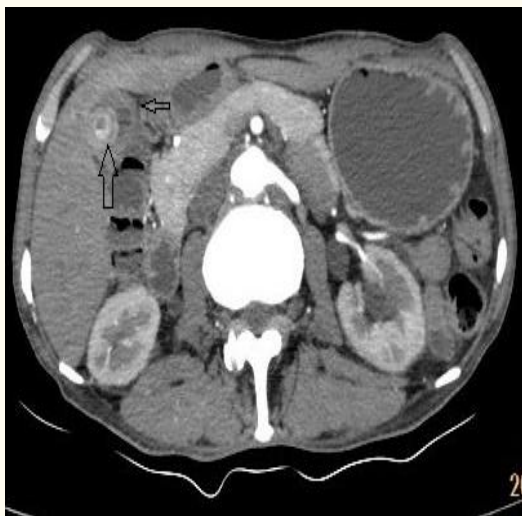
Axial contrast enhanced CT image shows a lamellated calculus in the fundal region (long arrow) and diffusely thickened walls with intramural hypodense nodules and ulcerations (small arrow)
